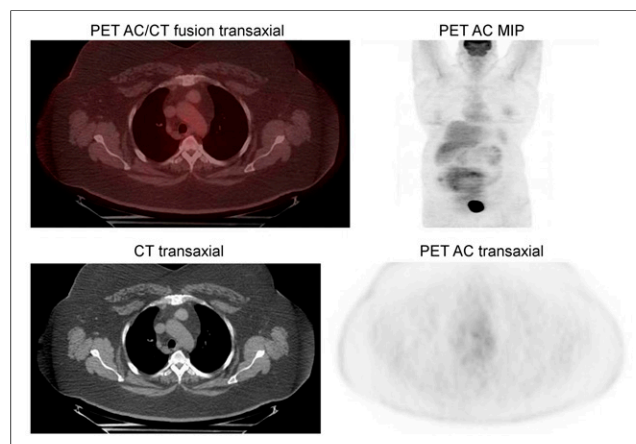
Non- ^{18}F -FDG avid anterior mediastinal mass. AC = attenuation corrected; MIP = maximum-intensity projection.
